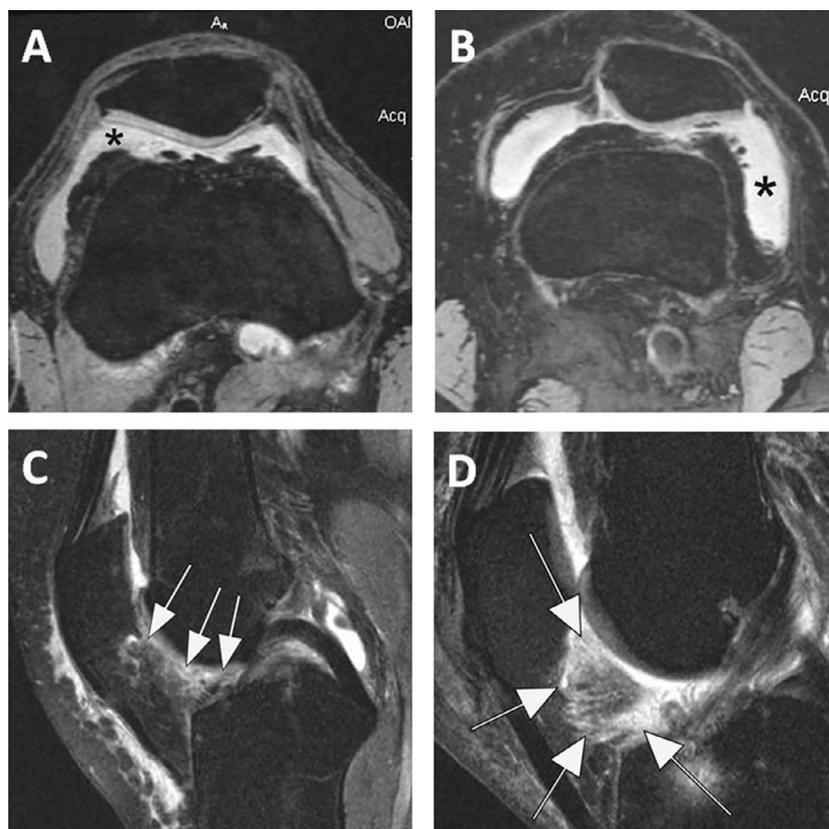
Magnetic resonance imaging (MRI) markers of inflammation in osteoarthritis (OA). Fluid-sensitive sequences are capable of delineating intraarticular joint fluid. However, a distinction between true joint effusion and synovial thickening is not possible, as both are visualized as a hyperintense signal within the joint cavity. For this reason, the term effusion-synovitis was introduced, which in the MRI OA Knee Score system is scored based on the distension of the joint capsule and is graded from 0 to 3 in terms of the estimated maximal distention of the synovial cavity, with 0 = normal, grade 1 = <33% of maximum potential distention, grade 2 = 33–66% of maximum potential distention, and grade 3 = >66% of maximum potential distention. Axial dual-echo steady-state MRI shows grade 2 effusion-synovitis (asterisk) (A) and grade 3 effusion-synovitis (asterisk) (B). In addition, signal changes in Hoffa's fat pad are commonly used as a surrogate for synovitis (C). Sagittal intermediate-weighted fat-suppressed MRI shows a discrete ill-defined hyperintense signal alteration in Hoffa's fat pad consistent with grade 2 Hoffa-synovitis (arrows) (D). Severe, grade 3 signal alterations almost occupying the entire fat pad are seen in this image (arrows).
